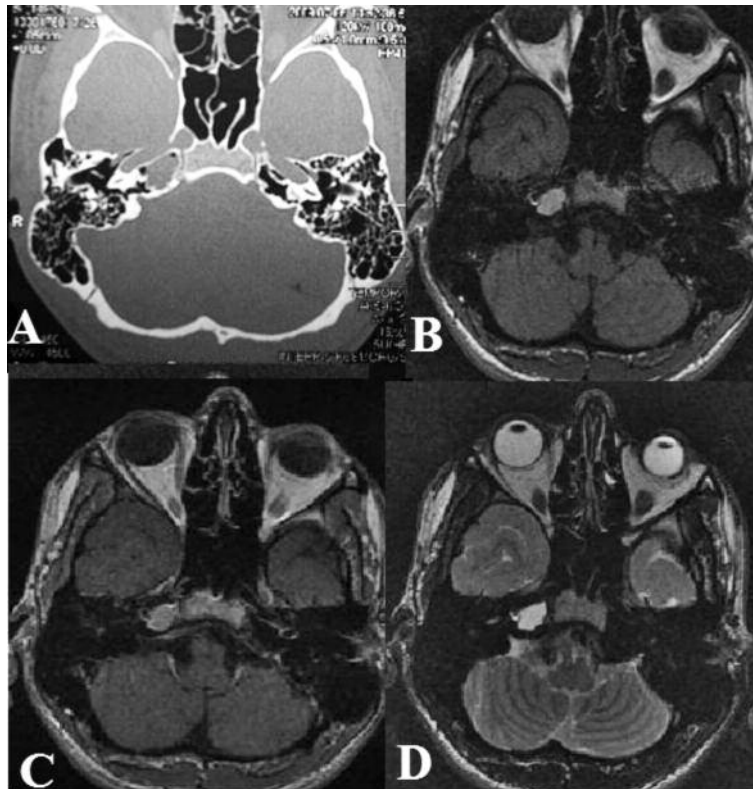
Cholesterol granuloma in right PA. A: Axial CT shows a smoothly expansile lesion with the destruction of trabeculae; B: Axial T1 WI shows a hyperintense lesion; C: Axial T1 WI with contrast shows no enhancement; D: Axial T2 WI shows a hyperintense lesion.
